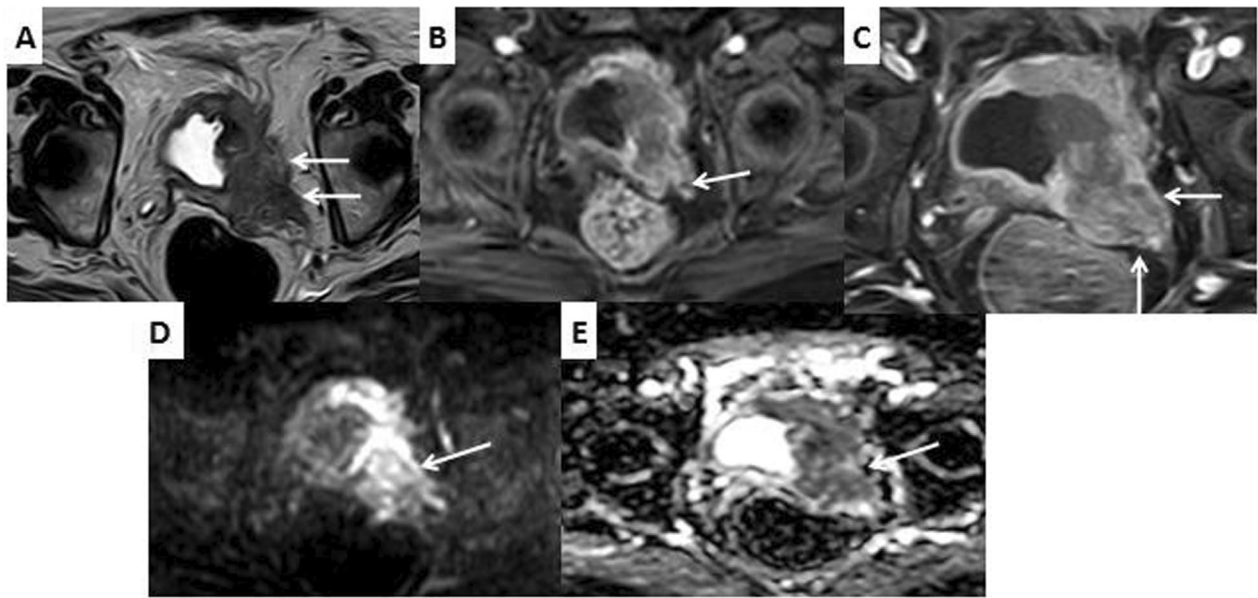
A T2-WI shows tumor at the anterior and left posterolateral sides of the bladder with extravesical tumor mass (arrows), SC category 5. B, C Axial DCE with early and delayed phases shows enhancement of the tumor at the anterior and left posterolateral walls with extravesical mass (arrows), CE category 5. D, E Axial DWI and ADC map show restricted diffusion of the tumor with ADC value $0.694 \times 10^{-3} \text{ mm}^2/\text{s}$ at the anterior and left posterolateral walls with extravesical mass (arrow), DW category 5. Final VI-RADS score is 5, meaning that invasion of muscle and beyond the bladder is very likely. Pathology proved high-grade TCC with invasion of the muscularis propria
